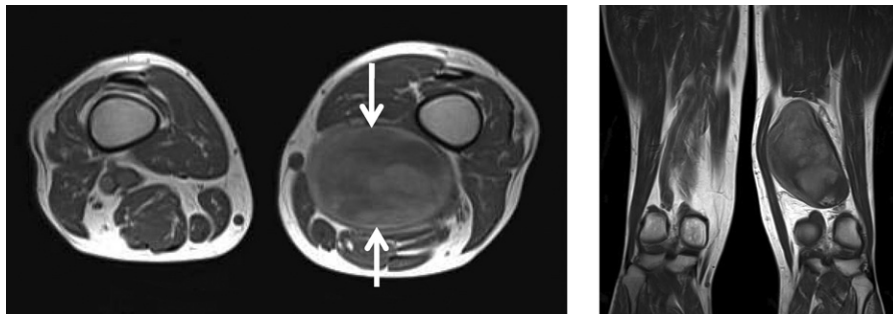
Magnetic resonance images show an expanding 8- × 12-cm popliteal artery aneurysm (arrows), 8 years after double ligation and medial bypass.
